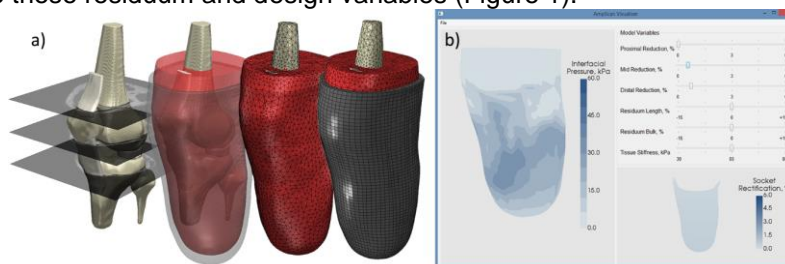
a) FEA model development process from MRI, b) Software environment used to explore how socket design and patient anatomy affects residuum pressure
